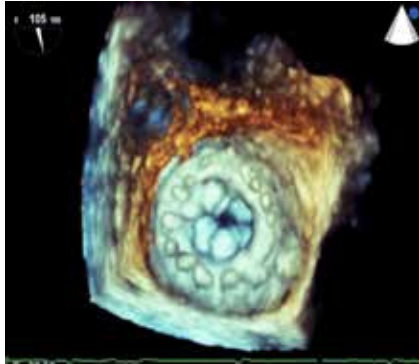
Transesophageal echocardiography demonstrating the significantly degenerated 29-mm Hancock II biological mitral valve. The ring is well identified.
